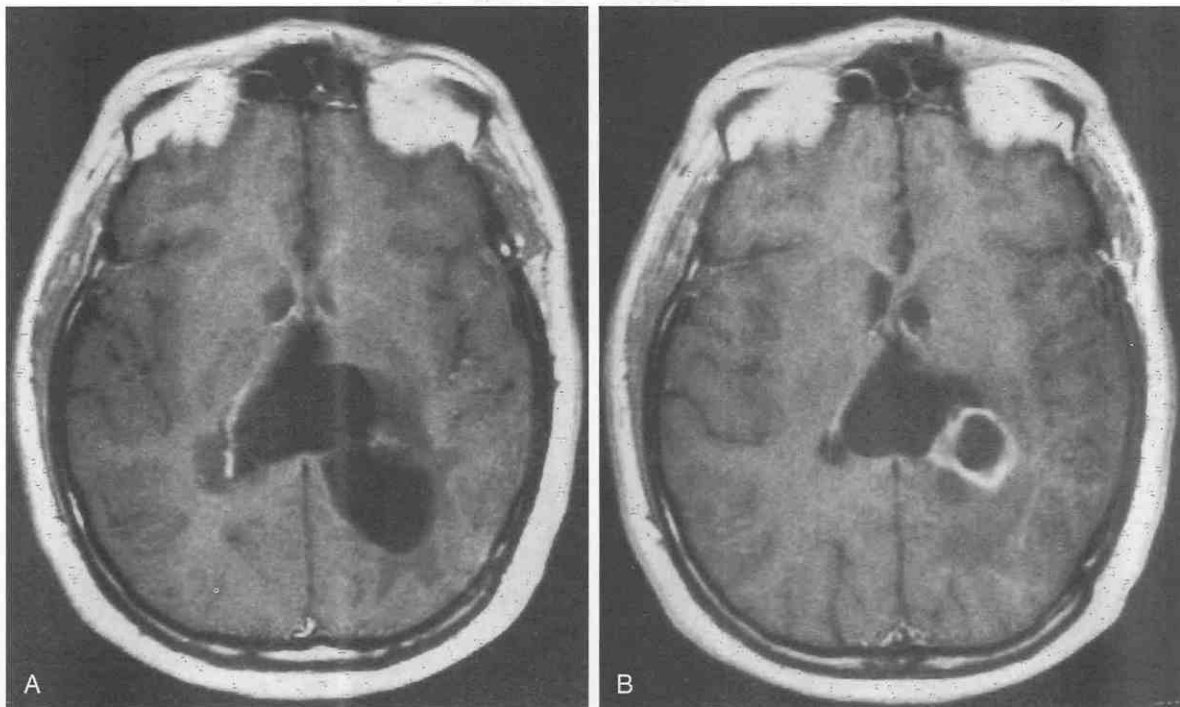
Recurrent echinococcosis. A, Gadolinium-enhanced MRI study shows recurrent cysts. No contrast enhancement is seen at this stage. B, Gadolinium-enhanced MRI study obtained a year later shows a decrease in the size of these cysts and contrast enhancement of one of the cysts.
